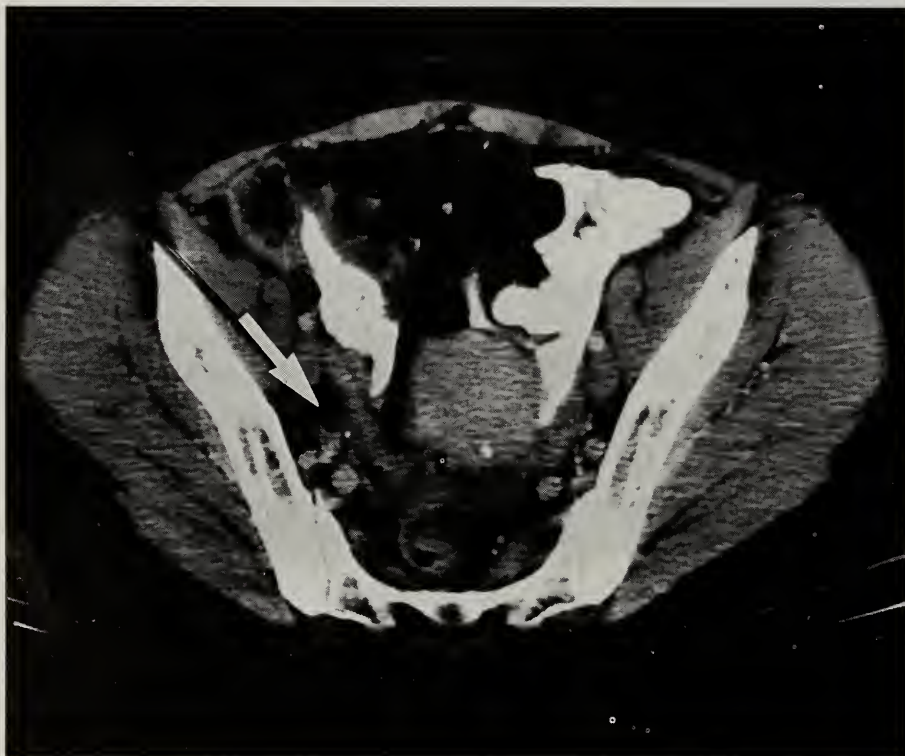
CT scan of pelvis. Arrow points to dilated distal ureter with no obvious extrinsic mass.
